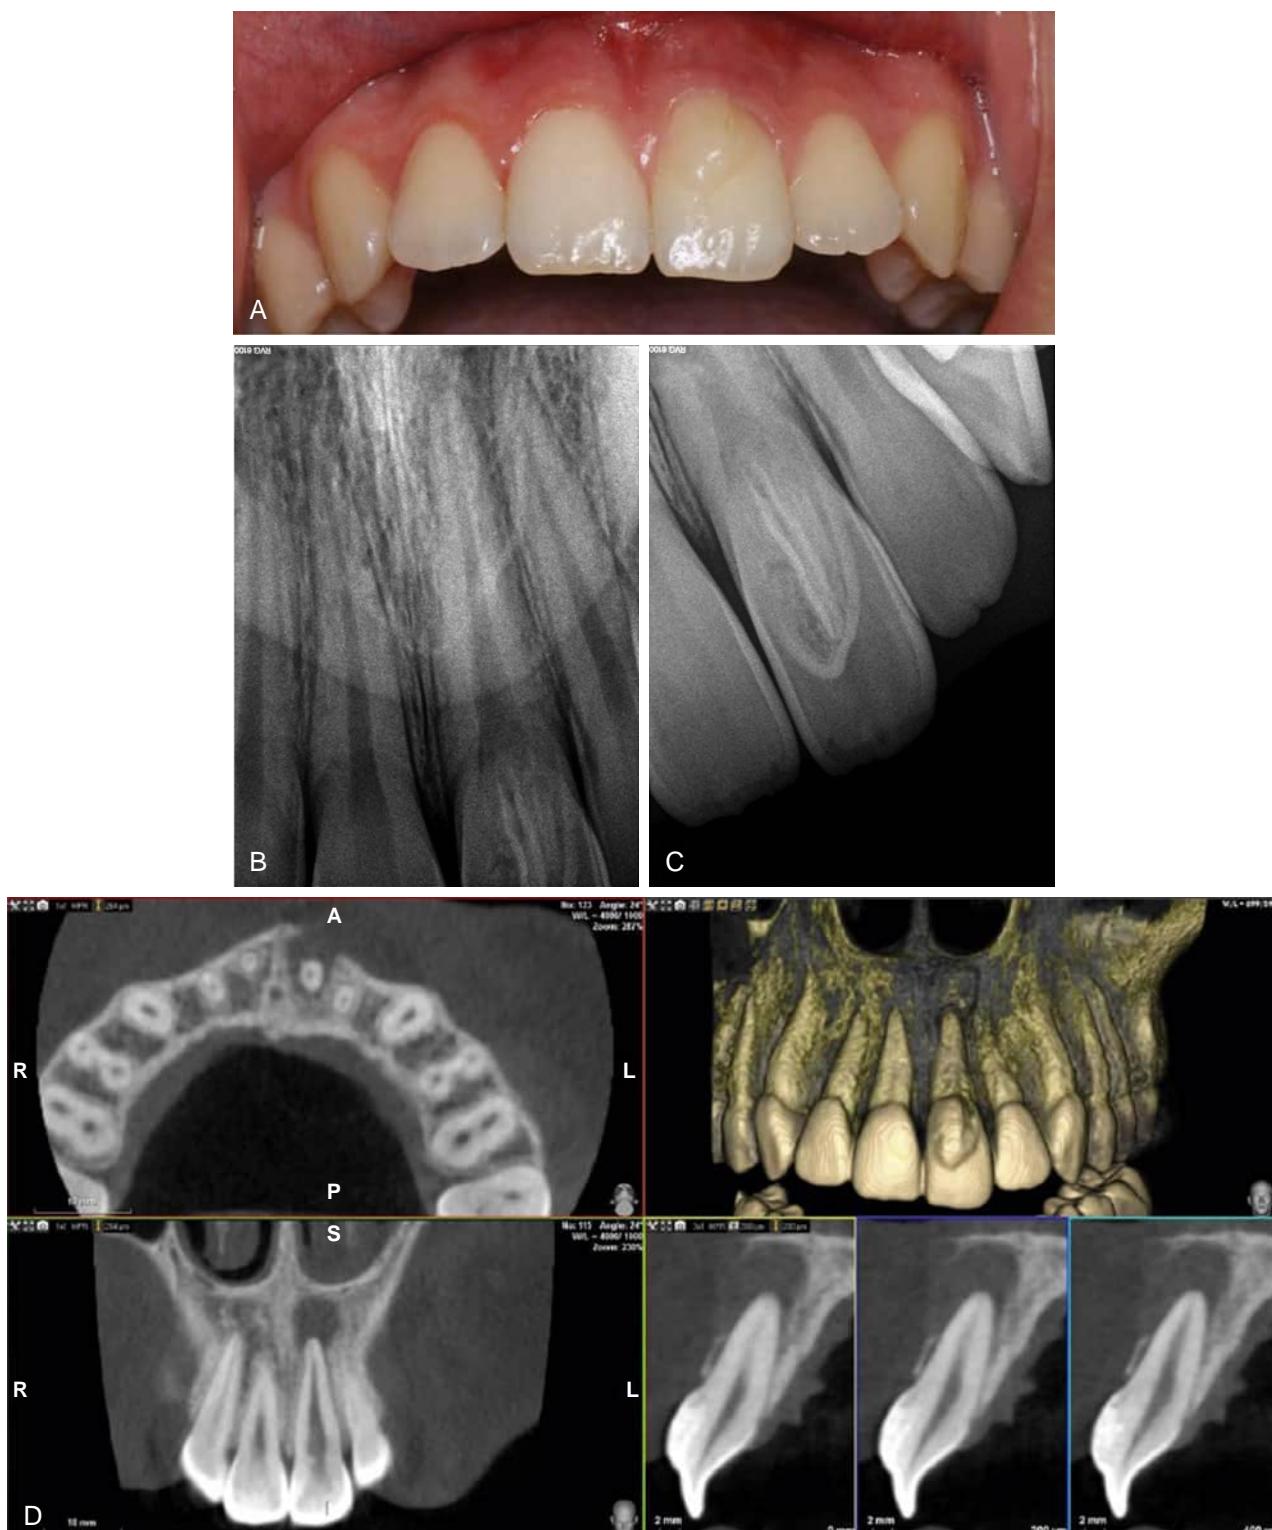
Dens evaginatus (talon cusp) presenting on the buccal surface of the central incisor of a 16-year-old Caucasian female. (A) Visual examination. (B and C) Intraoperative periapical radiograph of dens evaginatus on the incisor. (D) Cone beam computed tomographic (CBCT) sagittal cross-section shows a periapical lesion and the presence of the dens evaginatus. A, Buccal; I, incisal; mm, millimeter; P, palatal; S, apical. (Reproduced from *Journal of Esthetic and Restorative Dentistry*, Vol. 29, Mena-Alvarez J, Rico-Romano C, Lobo-Galindo AB, Zubizarreta-Macho A, Endodontic treatment of dens evaginatus by performing a splint guided access cavity., pages 396–402, (Copyright 2017), <https://doi.org/10.1111/jerd.12314>; with permission from John Wiley and Sons Publisher.)
